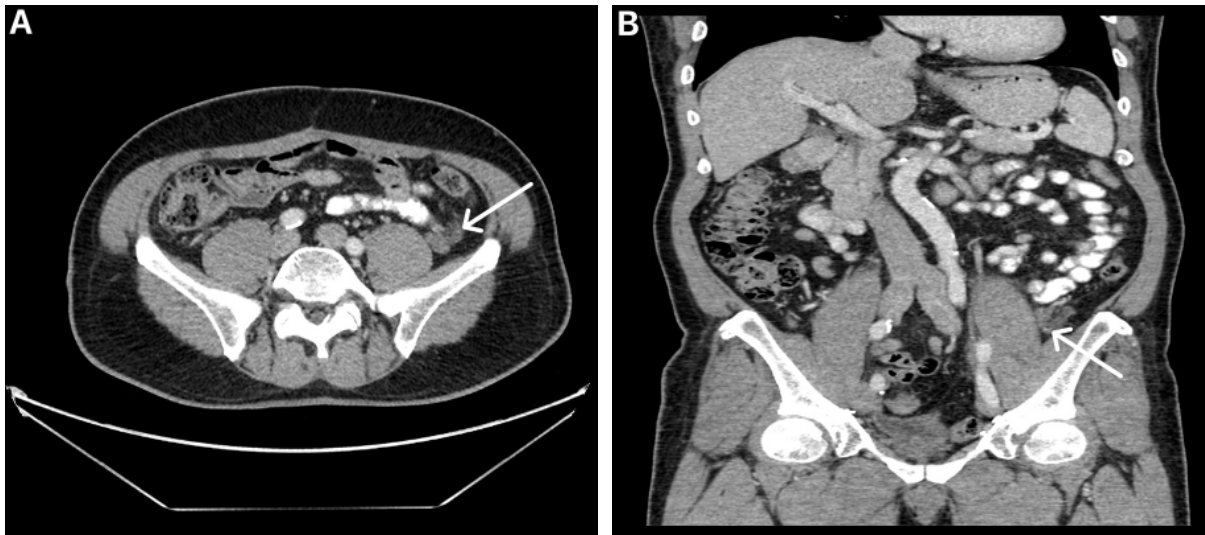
59-year-old male with urachal liposarcoma. 4th year postoperative surveillance CT.
